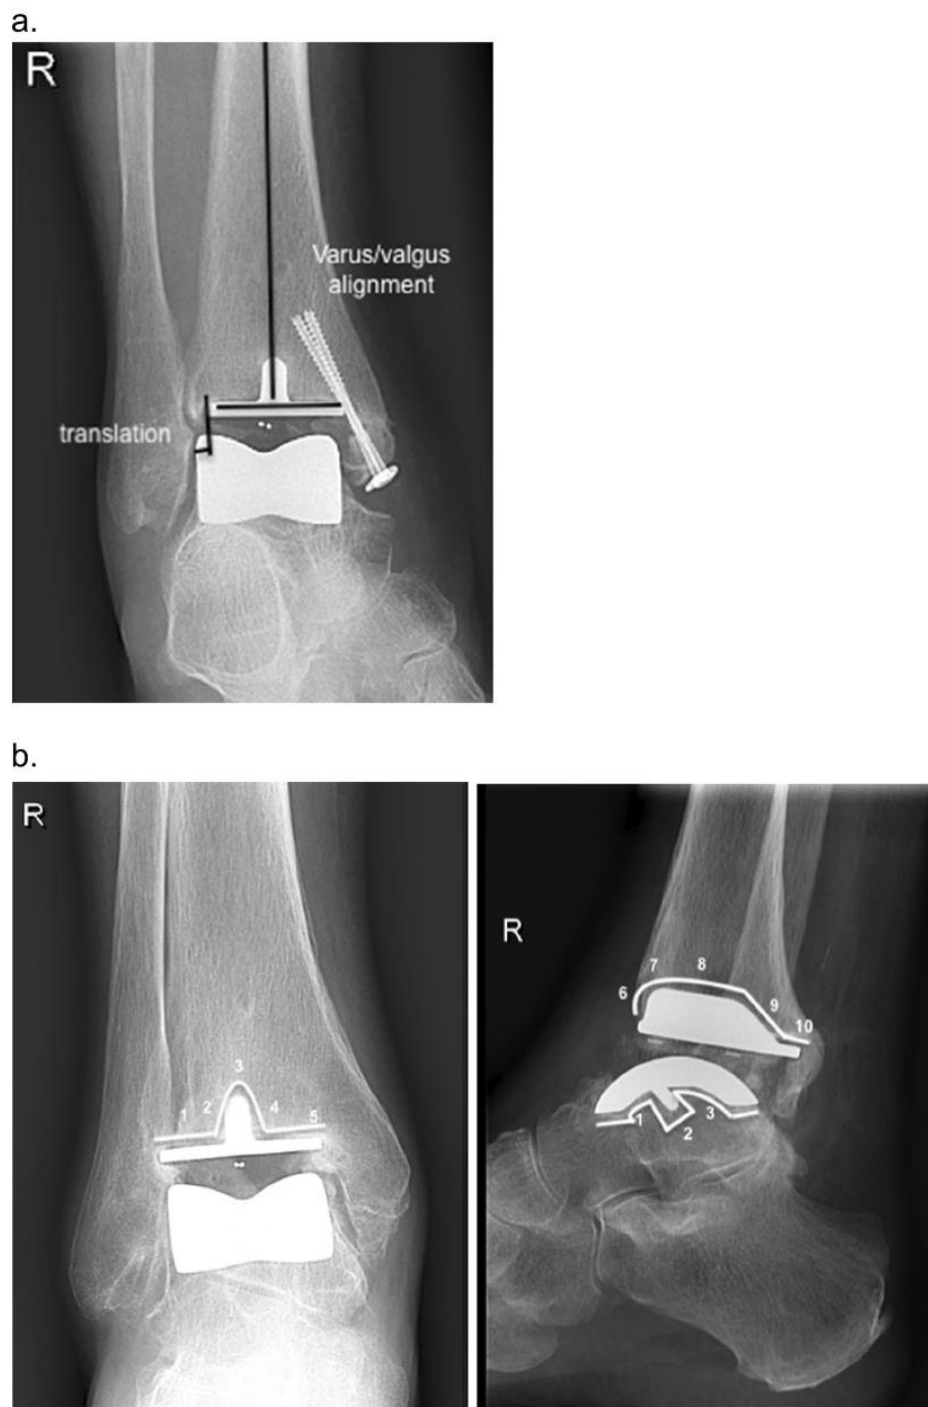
Visualisation of X-ray angle measurement for alignment and migration assessment according to Rippstein protocol (18). a Measurement varus/valgus alignment and translation. b Zones of radiolucency
